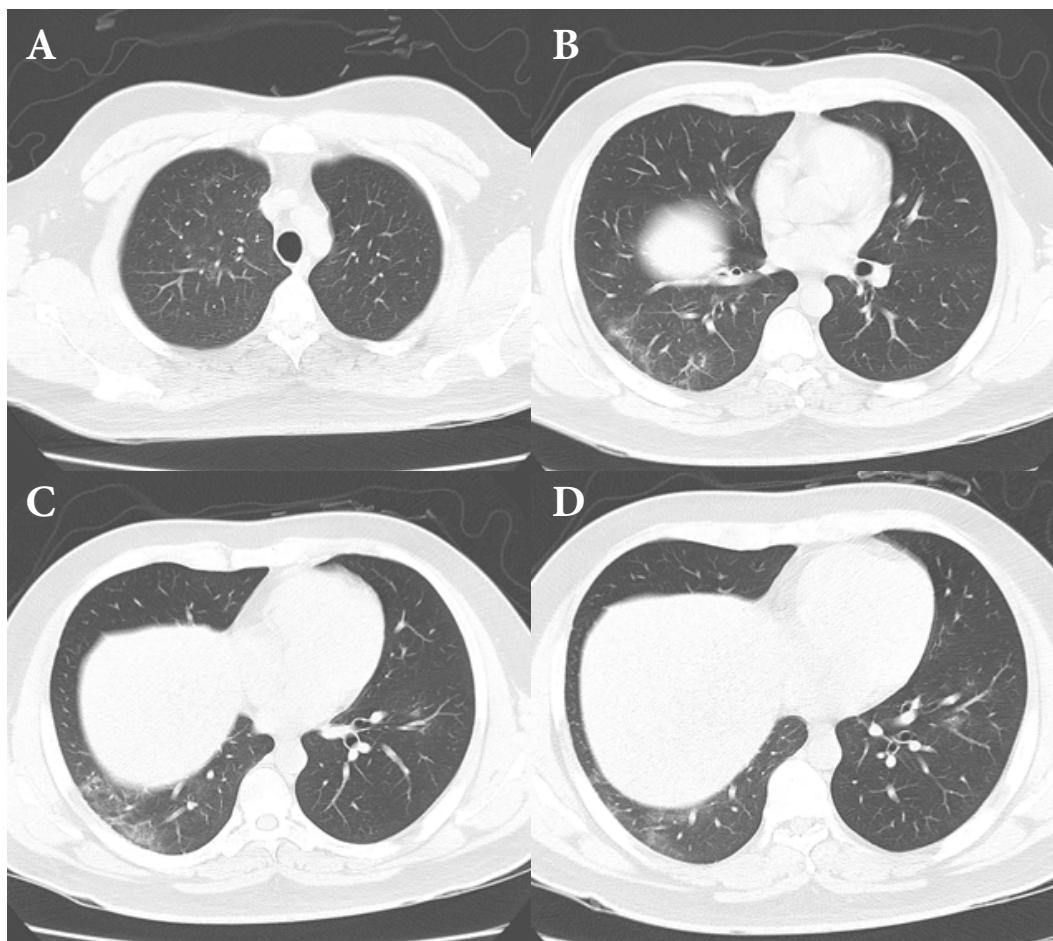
The axial non-contrast chest CT (A-D) shows partial resolutions of GGO at both upper lobes and both lower lobes. The previously seen subpleural consolidation at the right lower lobe has turned into GGO.
